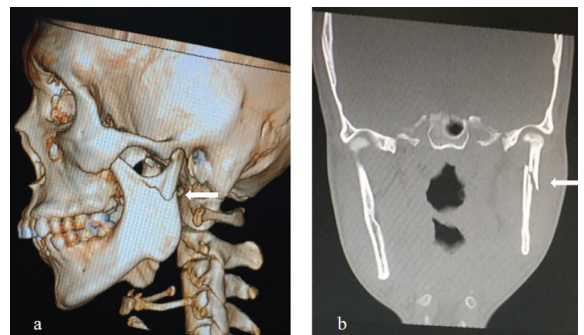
Demonstrated moderated displaced left subcondylar fracture (arrow): a) 3-dimension demonstration, b) coronal view in CT facial bone.
